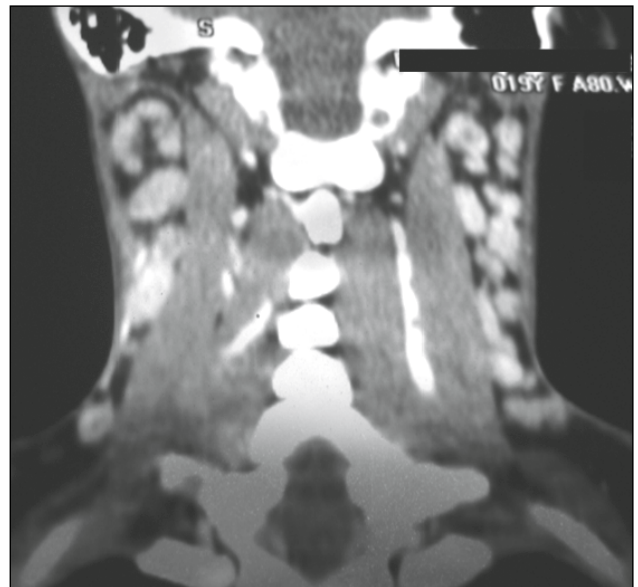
Coronal CT scan of the neck showing lymph nodes with central caseation.
